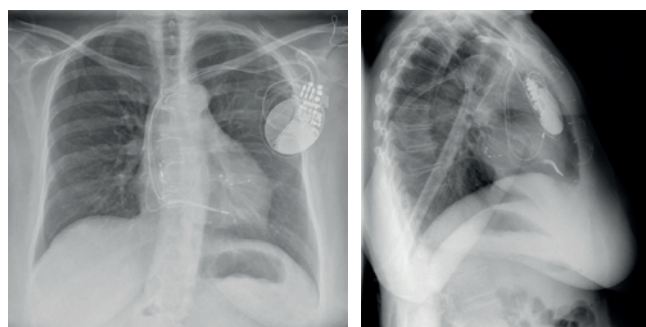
Post-procedural chest radiograph following CRT-D implant 8 years previously (left = posteroanterior, right = lateral projection). Three pacing leads can be seen in the expected positions: right atrial appendage, a defibrillation lead at the apex of the right ventricle, and in a posterolateral branch of the coronary sinus. Sternal wires noted in keeping with previous sternotomy for CABG surgeries.
